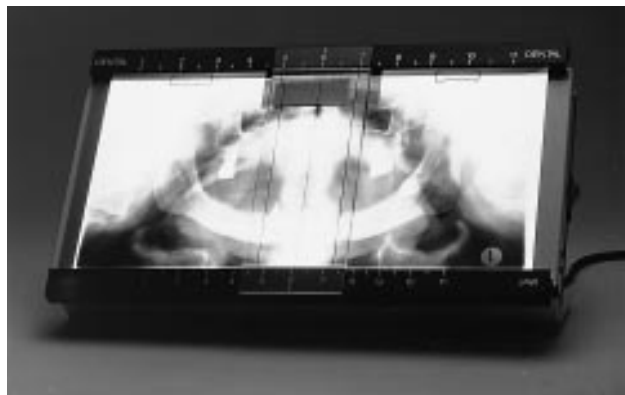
Light box with radiograph demonstrating localization of co-ordinates for programme.
